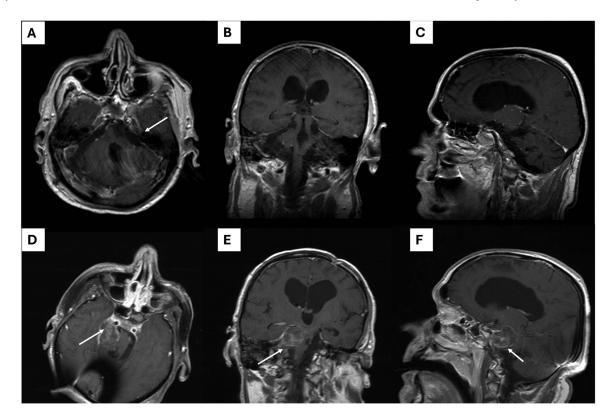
Recurrent Clival Chordoma in a 64-year-old male patient with prior L sided retro-sigmoid craniotomy and gross total tumor resection, now presenting with new R sided lesion after presenting with an episode of right facial numbness, dysphasia and left sided hemiparesis, 6 years after index surgery. He underwent a repeat craniotomy with a right suboccipital approach for intralesional curettage and gross total excision of underlying recurrent mass. Axial (A), Coronal (B) and Sagittal (C) post-gadolinium T1 MRI brain sequences showing post-surgical changes of L sided retro-sigmoid craniotomy (arrows) with gross total resection of L clival mass. Follow up MRI brain with post-gadolinium T1 Axial (D), Coronal (E) and Sagittal (F) sequences obtained 6 years after initial surgery, showing a new heterogeneously enhancing R petroclival mass (arrows) with mass effect and compression of the R cerebral peduncle. Note the new artifact posteriorly from a shunt that was placed for management of hydrocephalus following his initial tumor resection surgery.
